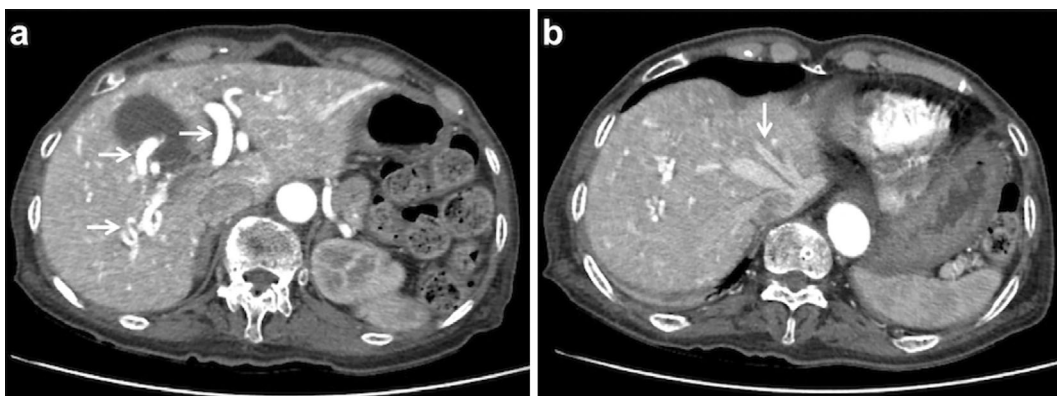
Contrast-enhanced computed tomography showed dilation and tortuosity of the intrahepatic and extrahepatic arteries (a, arrows) and early enhancement of the hepatic vein in the early arterial phase (b, arrow). These findings were consistent with AVMs. AVMs: arteriovenous malformations
